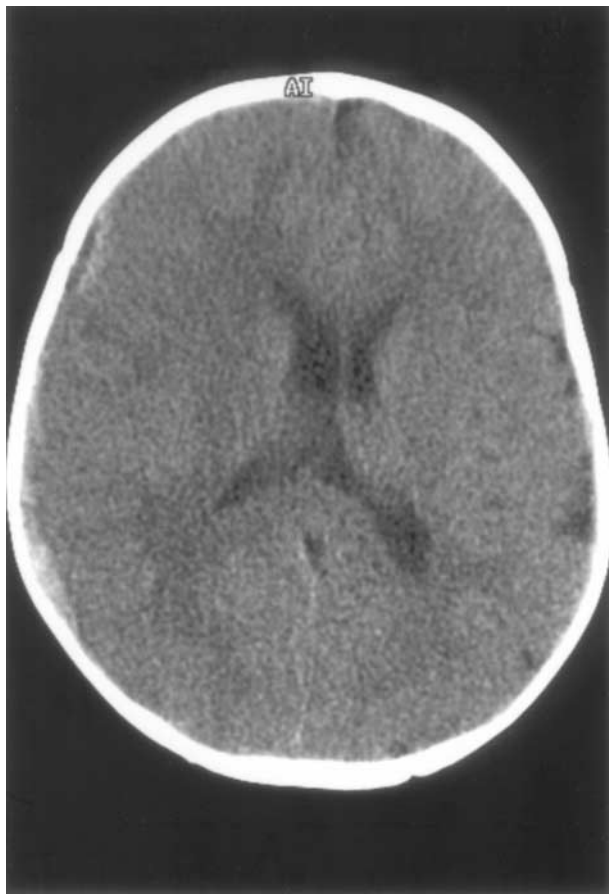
This 11-Month-Old Boy Was Hospitalized and Treated With Intravenous Fluids for His Recurrent Vomiting and Irritability. He Was Readmitted One Month Later With Persistent Clinical Signs. Neurological Exam at That Time Was Nonfocal and His Caregivers Denied Knowledge of Closed Head Trauma. Nevertheless, CT Scan Revealed a Nonacute Subdural Hematoma Overlying the Right Cerebral Hemisphere, Swelling of the Right Cerebral Hemisphere With Midline Shifting, and Probable Atrophy of the Left Cerebral Hemisphere.
